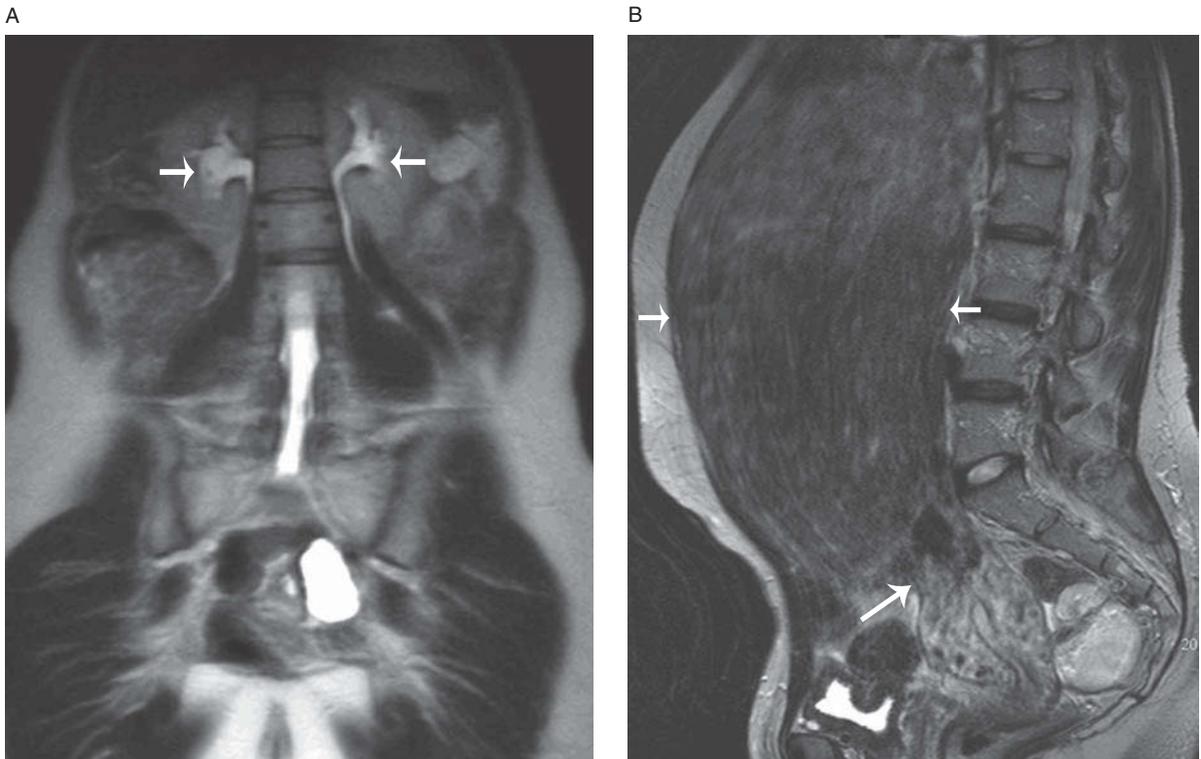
Mild bilateral hydronephrosis due to a large exophytic fundal fibroid in a 24-year-old female. Coronal T2-weighted image (A) demonstrates mild bilateral hydronephrosis (arrows). Sagittal T2-weighted image (B) further reveals a large exophytic fundal fibroid (short arrows) with a broad-based attachment to the uterus (long arrow) accounting for the hydronephrosis due to extrinsic ureteral compression.
